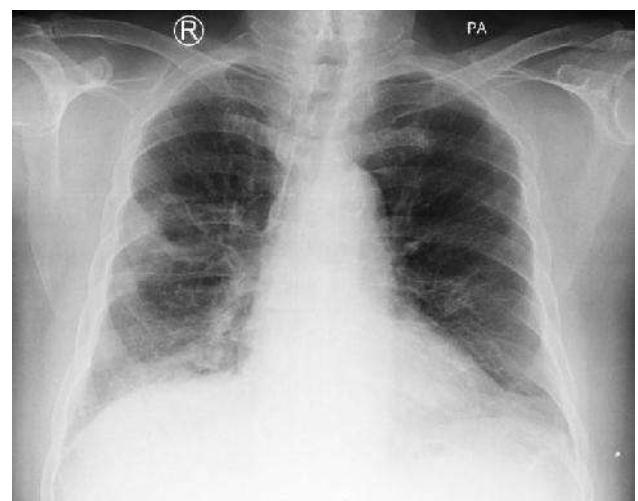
Chest X-Ray on our hospital admission day 8
